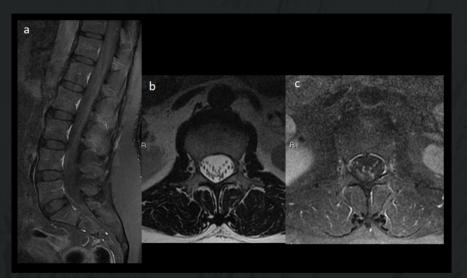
51-year-old woman with COVID lung disease and rapidly progressive flaccid paralysis. Guillain–Barré Syndrome on sagital T1 post-contrast (a), axial T2-weight image (b) and axial T1 post-contrast (c) on 1,5T MRI. Diffuse mild thickening and enhancement after intravenous gadolinium administration of the medullary cone and the roots of the conus medullaris, especially the anterior roots.
